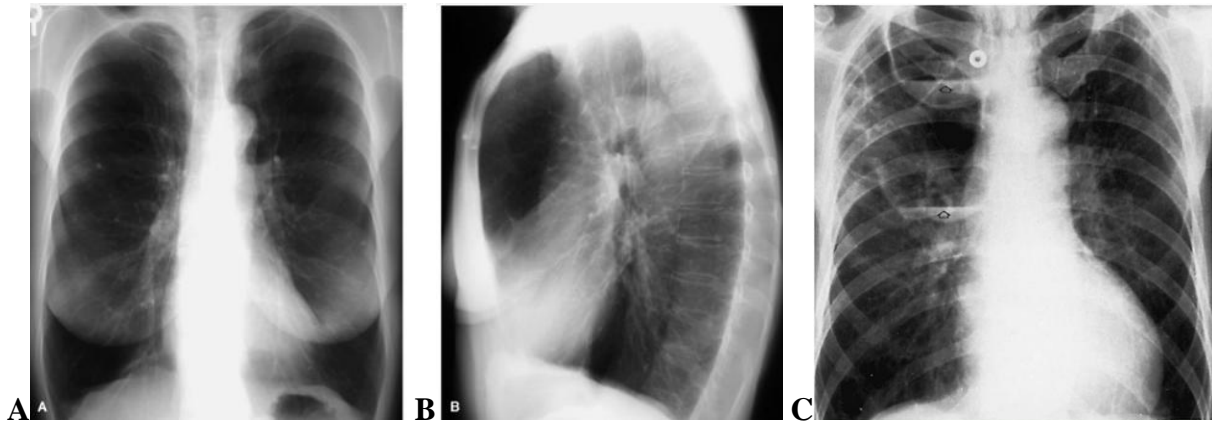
(A) Posteroanterior and (B) lateral chest radiographs with emphysema shows hyperinflation with hyperlucency, overexpanded lungs, narrow mediastinum, upper lobe vascular attenuation, flattening of the diaphragms, and an increased retrosternal airspace, reflecting severe bilateral lungs emphysema. (C) Pulmonary emphysema.
